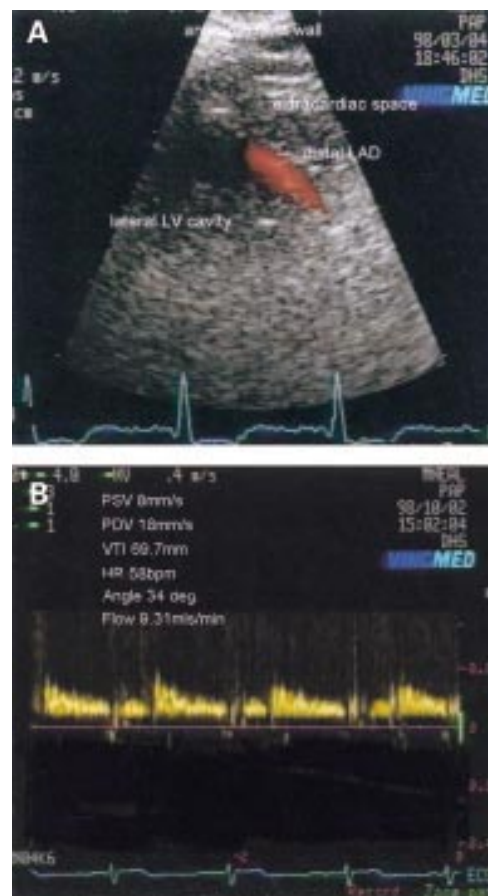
(A) Low left parasternal long axis window. Resting distal left anterior descending coronary artery (LAD) flow is visualised as a thin red diastolic flame once low velocity reject and frame rate are minimised. (B) Spectral Doppler display of resting flow in the distal LAD in an endurance athlete. HR, heart rate; PDV, peak diastolic velocity; PSV, peak systolic velocity; VTI, velocity-time integral.
